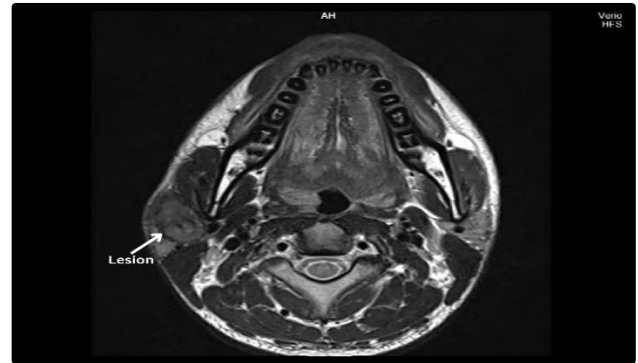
Cut section of MRI showing the lesion just inferior to the superficial lobe of the parotid gland.
